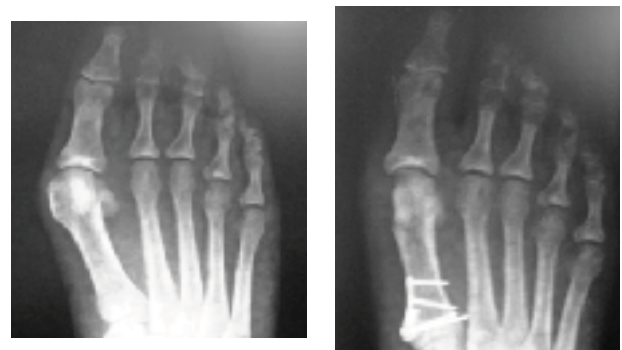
Pre-op and 2 year radiograph
